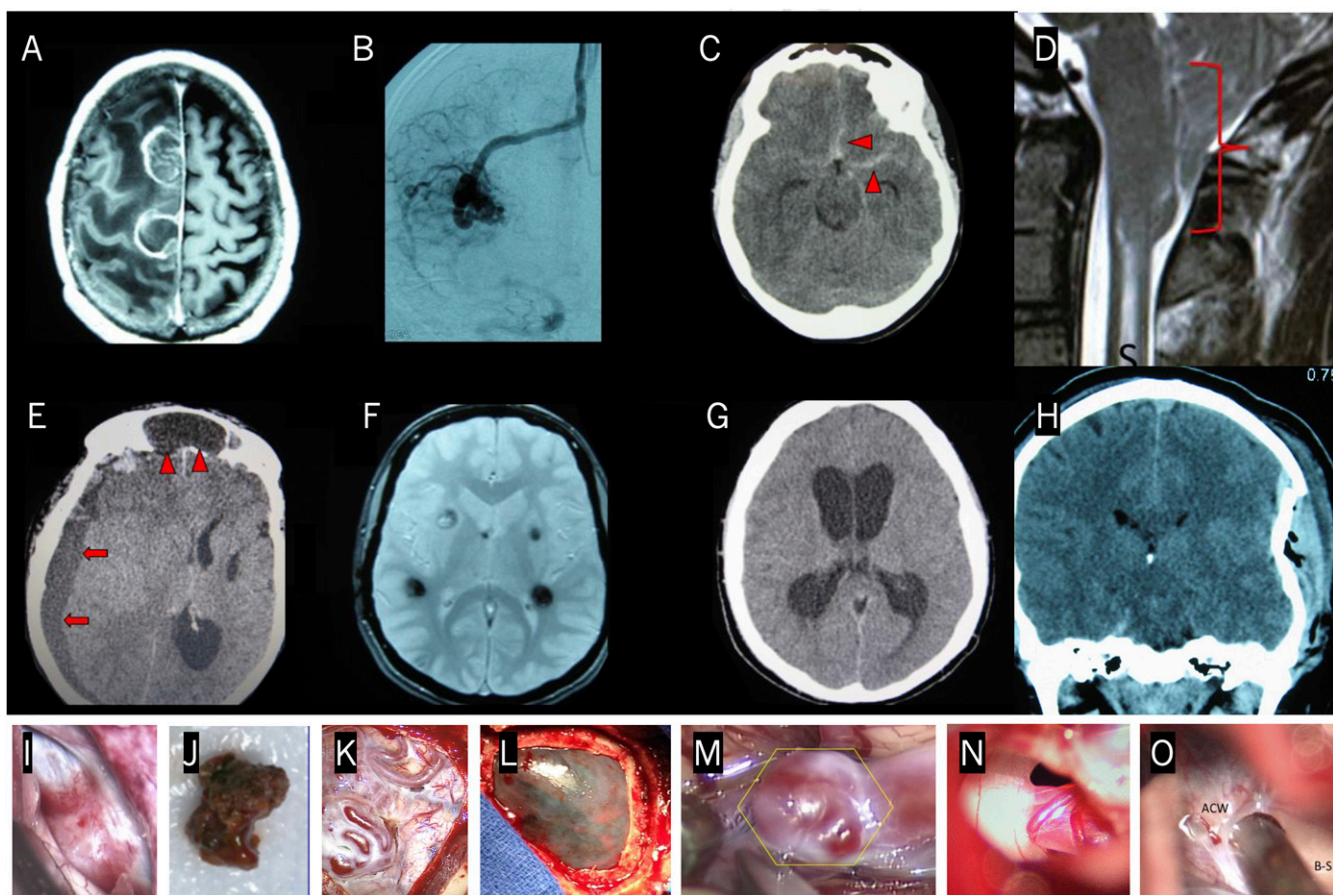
Some structural intracranial pathologies. A) MRI T1 axial postcontrast; multifocal brain cancer (glioblastoma multiforme; GBM) with unilateral cerebral edema. B) Catheter angiogram; arteriovenous malformation (AVM). C) CT axial noncontrast; ruptured intracranial aneurysm with subarachnoid hemorrhage (SAH). D) MRI T2 sagittal; Chiari I malformation with established cervical syrinx (s). E) CT axial postcontrast; subdural empyema (abscess) from chronic untreated sinusitis. F) MRI gradient echo axial; multiple cavernous malformations. G) CT axial; hydrocephalus; H) CT coronal; posttraumatic extradural hematoma (EDH) and open (compound) depressed skull fracture prior to evacuation and reconstruction. I) Skull base meningioma prior to excision. J) Excised brainstem cavernous malformation. K) AVM prior to excision. L) Posttraumatic subdural hematoma with glistening outer membrane on view prior to incision and evacuation. M) Intracranial aneurysm with ‘daughter sacs’ prior to surgical clipping. N) Trigeminal nerve compressed and deviated by superior cerebellar artery branch in a trigeminal neuralgia patient during microvascular decompression surgery. O) Arachnoid cyst membrane fenestrated in cyst decompression surgery. See the online version of this article (<https://doi.org/10.3357/AMHP.5744.2021>) for color.
